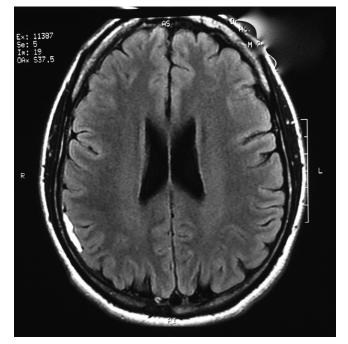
MRI showing right parietal subdural hematoma.
